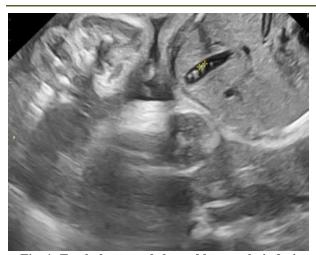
Fetal ultrasound showed hyperechoic foci giving comet tail V shape artifact within gall bladder and GB wall
